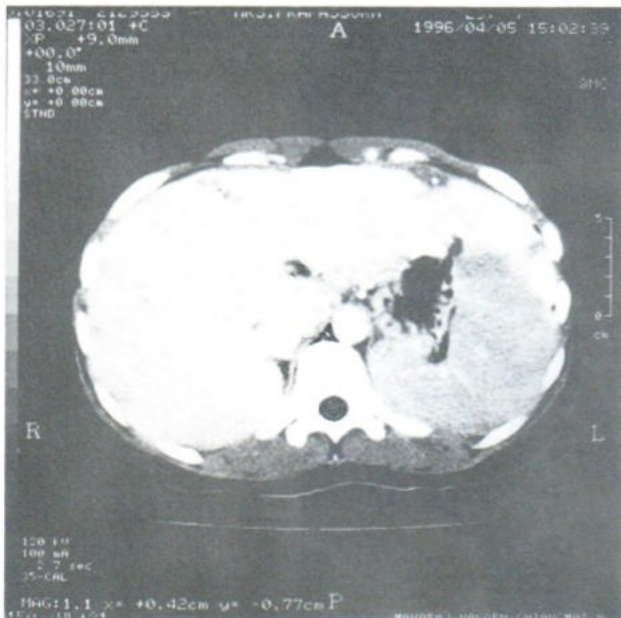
Delayed CT scan (10 minutes after contrast infusion) shows intense enhancement of multiple masses in the liver with multiple calcifications.
